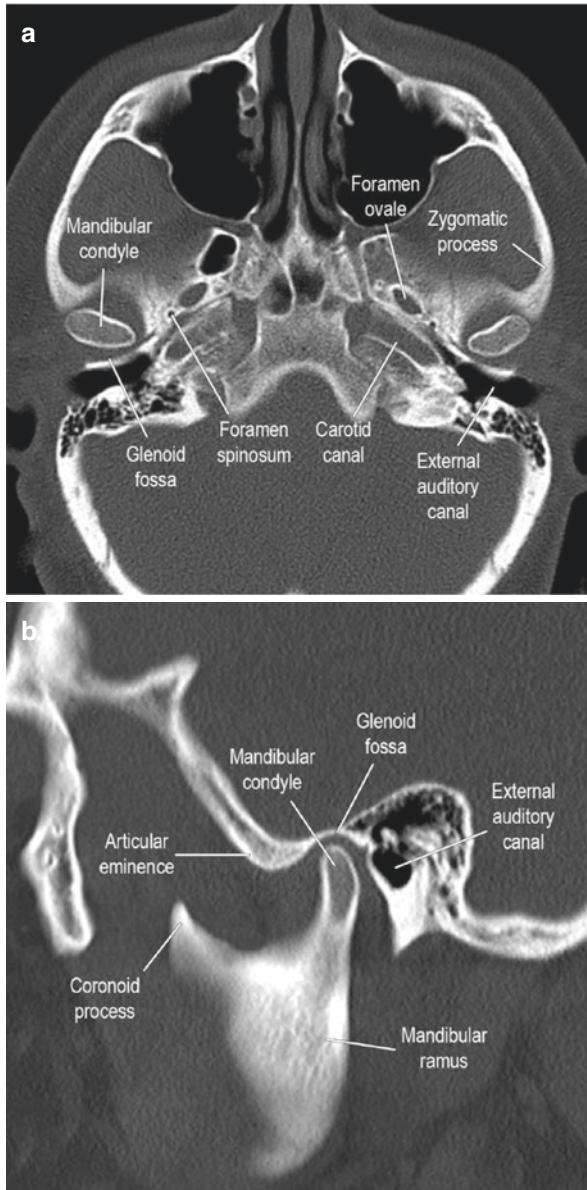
Axial (a) and sagittal (b) reformatted CT images demonstrating the normal anatomy of the TMJ. The mandibular condyle should be centered in the glenoid fossa between the articular eminence anteriorly and the EAC posteriorly
